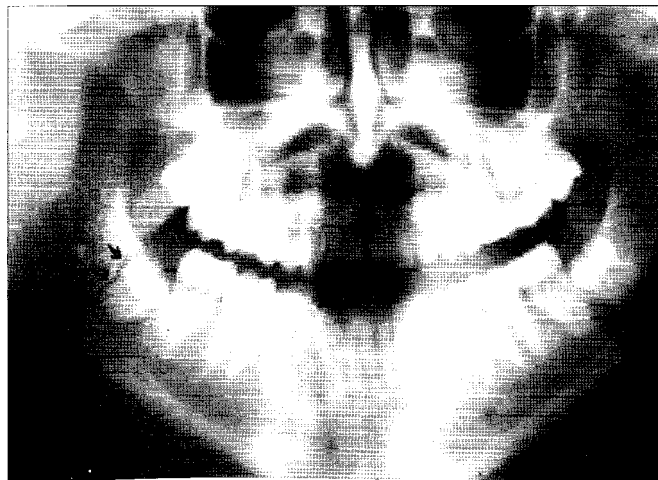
Orthopantomograph of the mandible shows a fracture (black arrows) involving right mandibular angle in the presence of an impacted third molar
